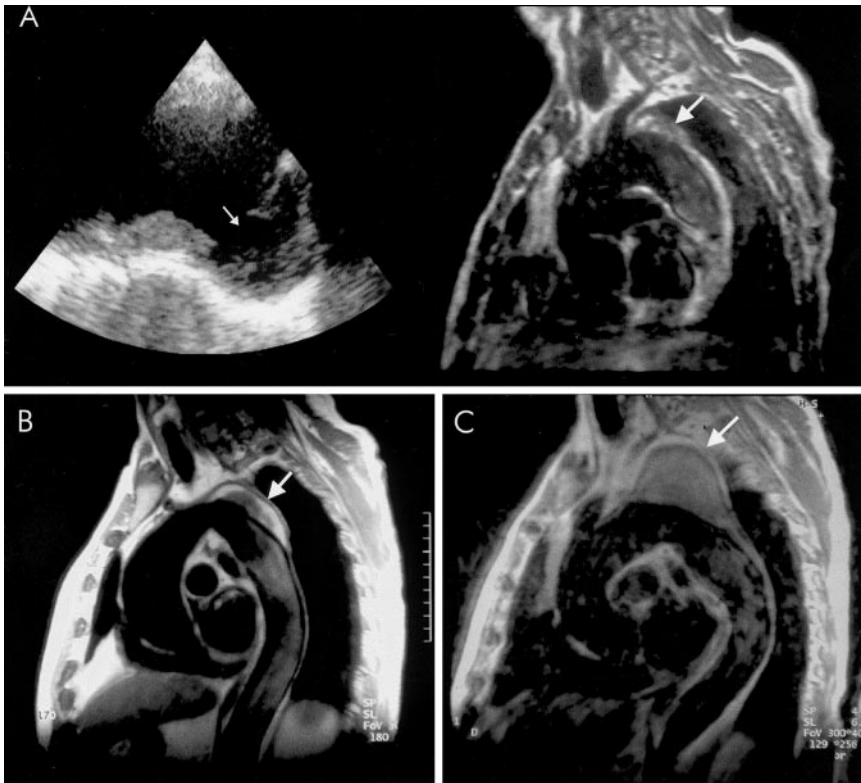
IMH evolution to saccular aneurysm. A, In acute phase, TEE (left) shows in transversal view an atherosclerotic ulcerated plaque (arrow) with IMH in the upper part of the descending aorta; MRI, T1-weighted, in sagittal view (right) reveals this ulceration (arrow) in the distal part of the aortic arch. B, MRI at 3 years reveals a high-density signal attributable to symptomless recurrent bleeding of the aortic wall. C, Seven years later, MRI shows a large saccular aneurysm (arrow) in the original site of the atherosclerotic ulcerated plaque.
